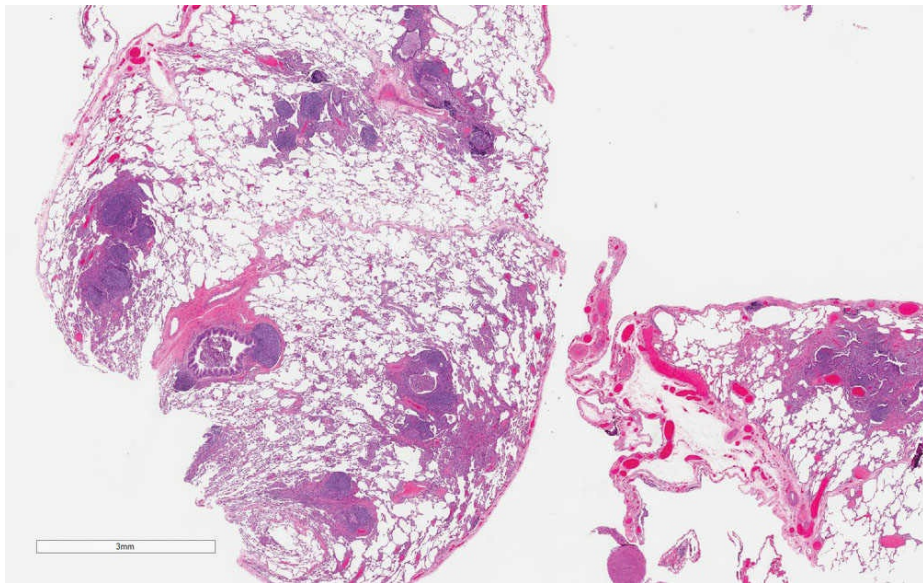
Follicular bronchiolitis: These peribronchial lymphoid infiltrates may be seen on HRCT as centrilobular nodules.
